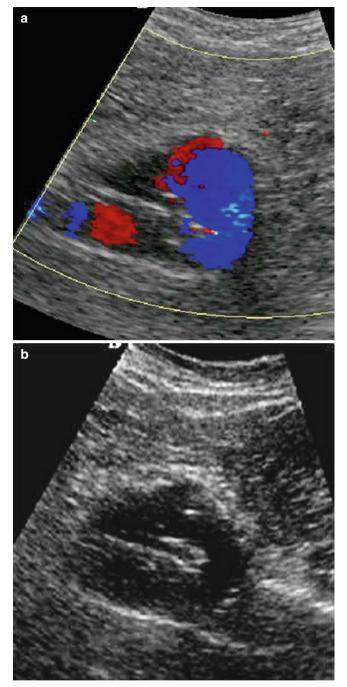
(a, b) Both color Doppler and B-mode images shows a detachment and kinking of left limb of the stent graft (Type I endoleak)
